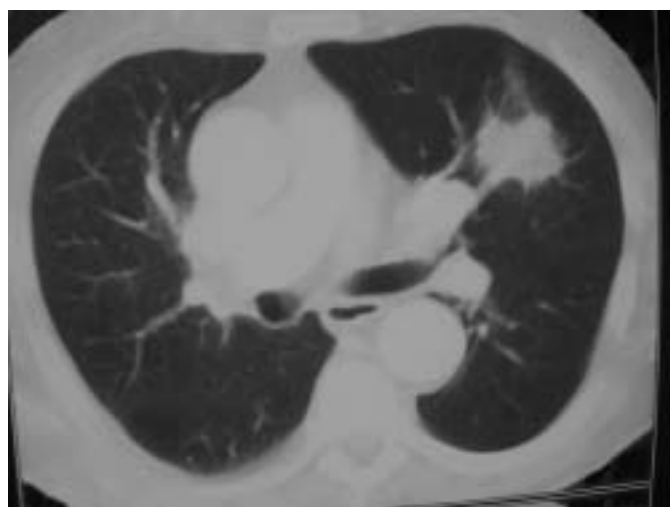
High-resolution computed tomography of cryptogenic organising pneumonia presenting as solitary focal opacity.
